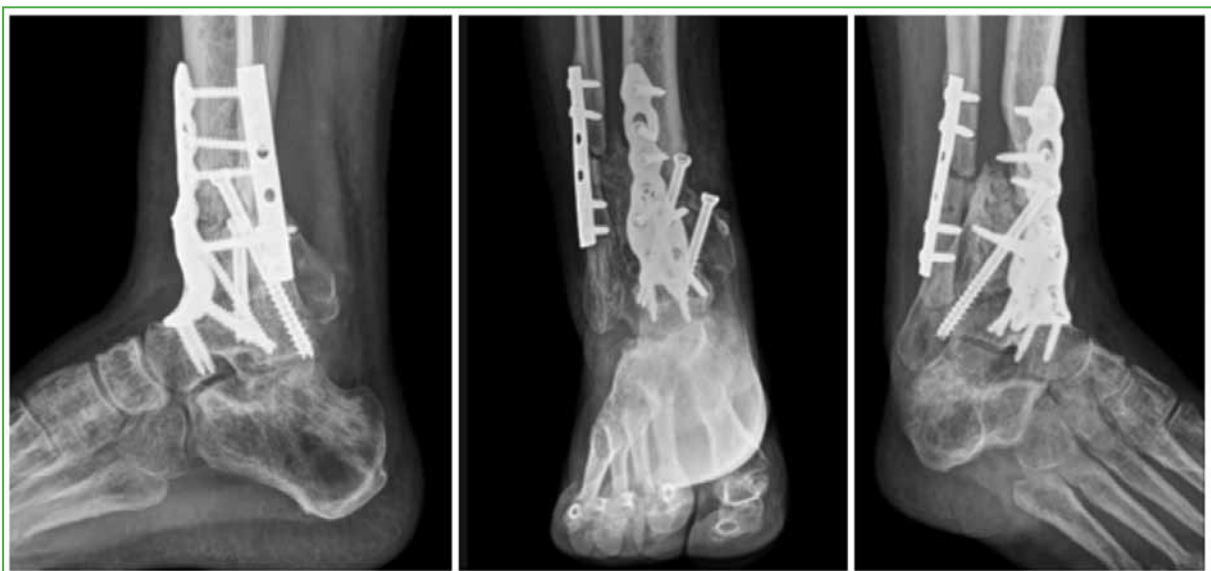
Anteroposterior, lateral and oblique ankle radiographs showing pseudarthrosis of a distal tibia with a failed ankle arthrodesis.
